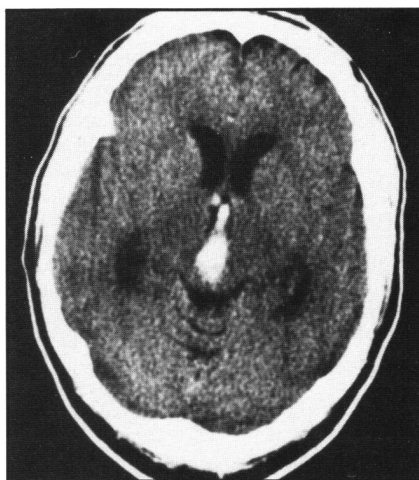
Admission CT scan of patient 2 showing mesencephalic tegmental hemorrhage, intraventricular hemorrhage and dilated lateral ventricles. Additional sections and scans on subsequent days revealed significant intraventricular hemorrhage and quadrigeminal plate cisternal involvement, respectively.
